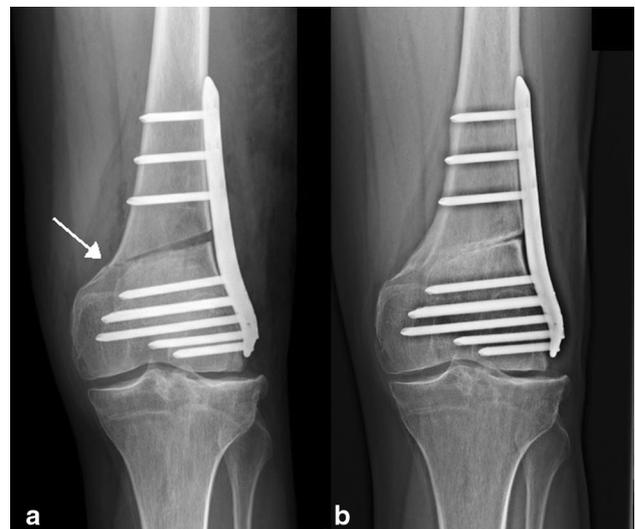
a Radiograph showing a biplane LOWDFO in a-p. view; an interruption of the medial cortex is evident (white arrow). b Same patient after 7 months. Although the medial cortex healed, a nonunion occurred in the lateral aspect
